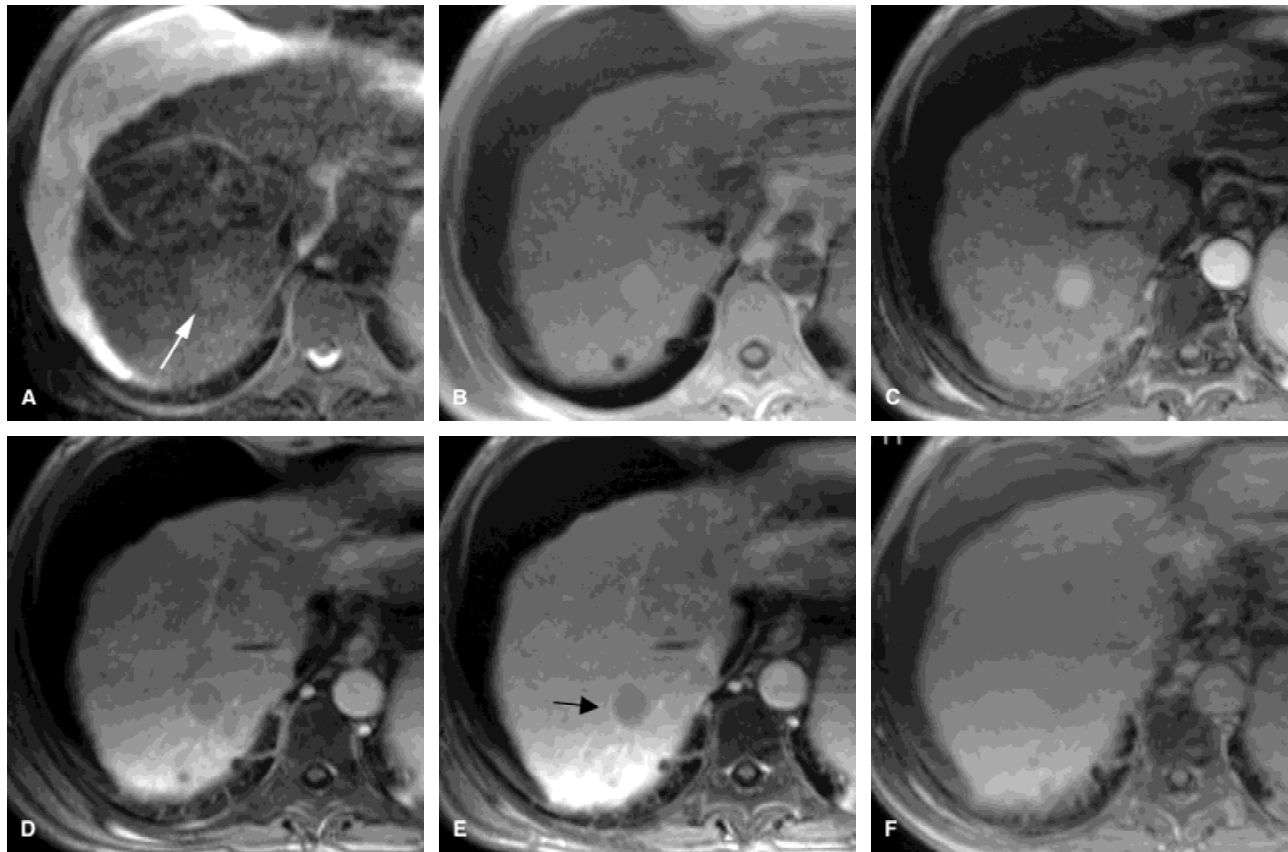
Hepatocellular carcinoma in a 53-year-old man with alcoholic cirrhosis. a: TSE T2-weighted transverse MRI shows a small nodule slightly hyperintense in the right lobe (arrow). b: On precontrast T1-weighted GRE transversal images the lesion is hyperintense. During dynamic imaging with bolus administration of Gd-BOPTA (GRE transverse T1-weighted), the lesion is hyperintense in the arterial phase (c) to become hypointense in the portal venous (d) and distribution phase (e). In this phase a peripheral capsule is well evident (arrow). f: In the hepatobiliary phase (GRE transverse T1-weighted) 2 hours after Gd-BOPTA injection the lesion is isointense.
